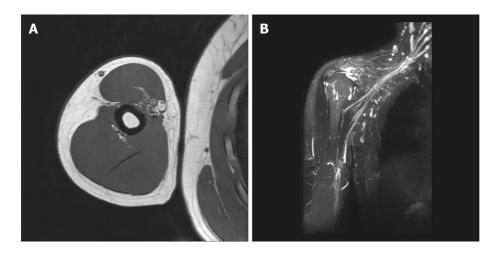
Right arm and brachial plexus magnetic resonance imaging. A: Transverse view; B: Coronal view. Significant abnormality was not observed in the right brachial plexus and distal peripheral nerves.
